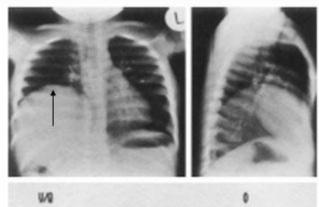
Eventration of the right diaphragm in an infant. Note that the diaphragm (arrow) is more up in the chest on the right when compared to the left side on the x-ray above. The lower image is a nuclear medicine scan of the lungs which shows a smaller lung on the right.
